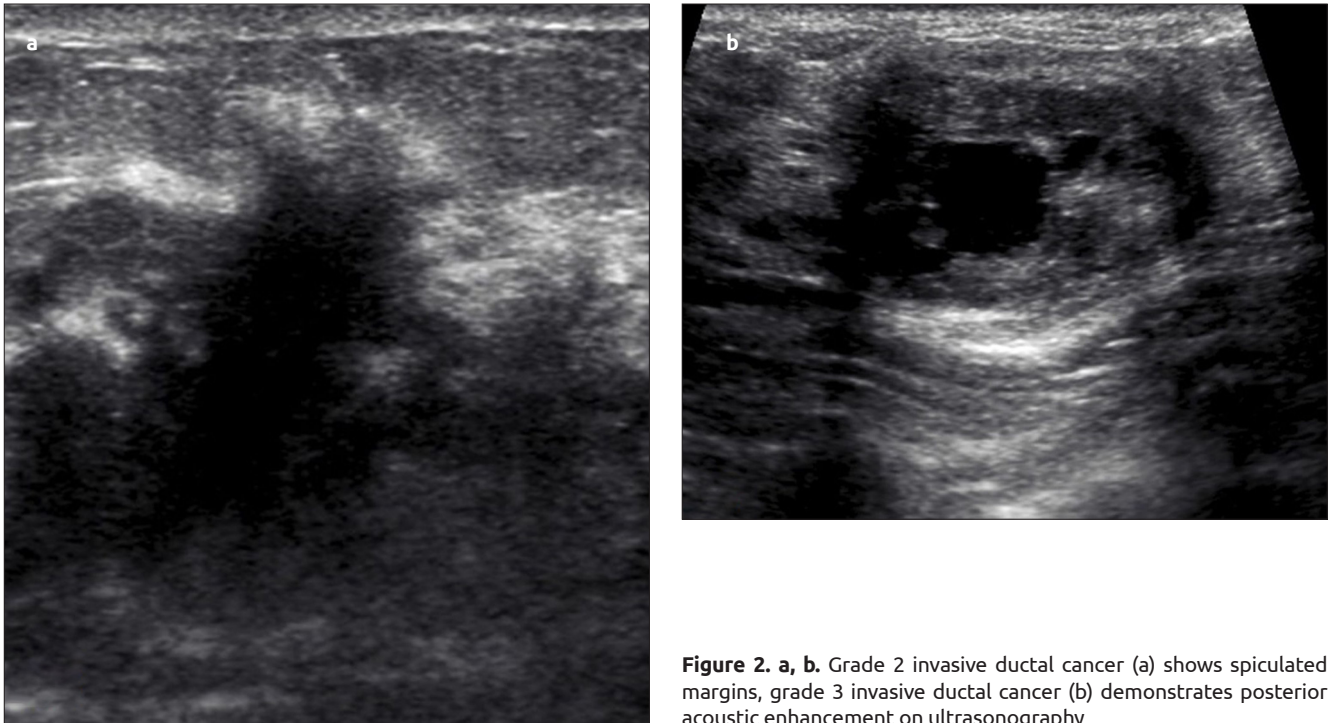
a, b. Grade 2 invasive ductal cancer (a) shows spiculated margins, grade 3 invasive ductal cancer (b) demonstrates posterior acoustic enhancement on ultrasonography
